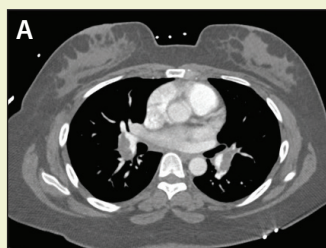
Axial CTA confirming clot present in both the upper and lower branches of the right (A) and left PA (B).
